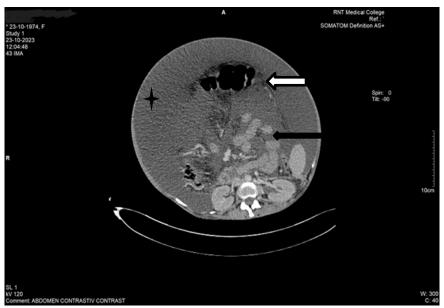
Shows Contrast enhanced axial CT scan of abdomen in which white arrow shows thick enhancing membrane surrounding bowel loops, black arrow shows clumped small bowel loops & + denotes gross ascites in abdominal cavity
